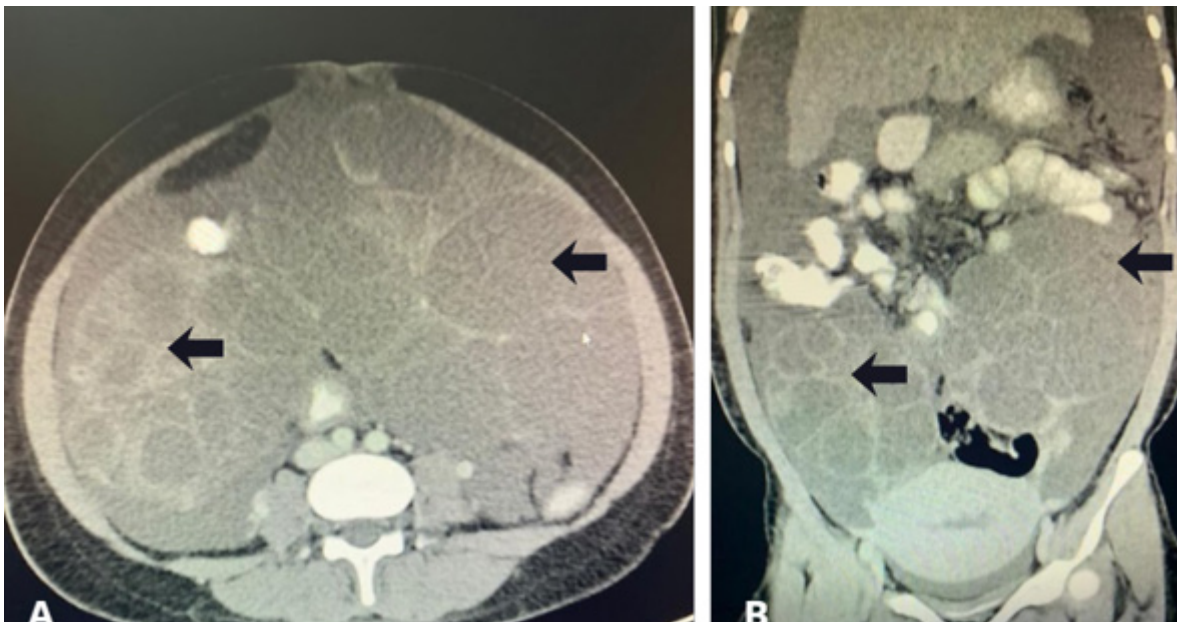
CONTRAST-ENHANCED COMPUTED TOMOGRAPHY; NOTE THE GIANT BILATERAL ADNEXAL MASSES (BLACK ARROWS). A: AXIAL VIEW; B: CORONAL VIEW.
